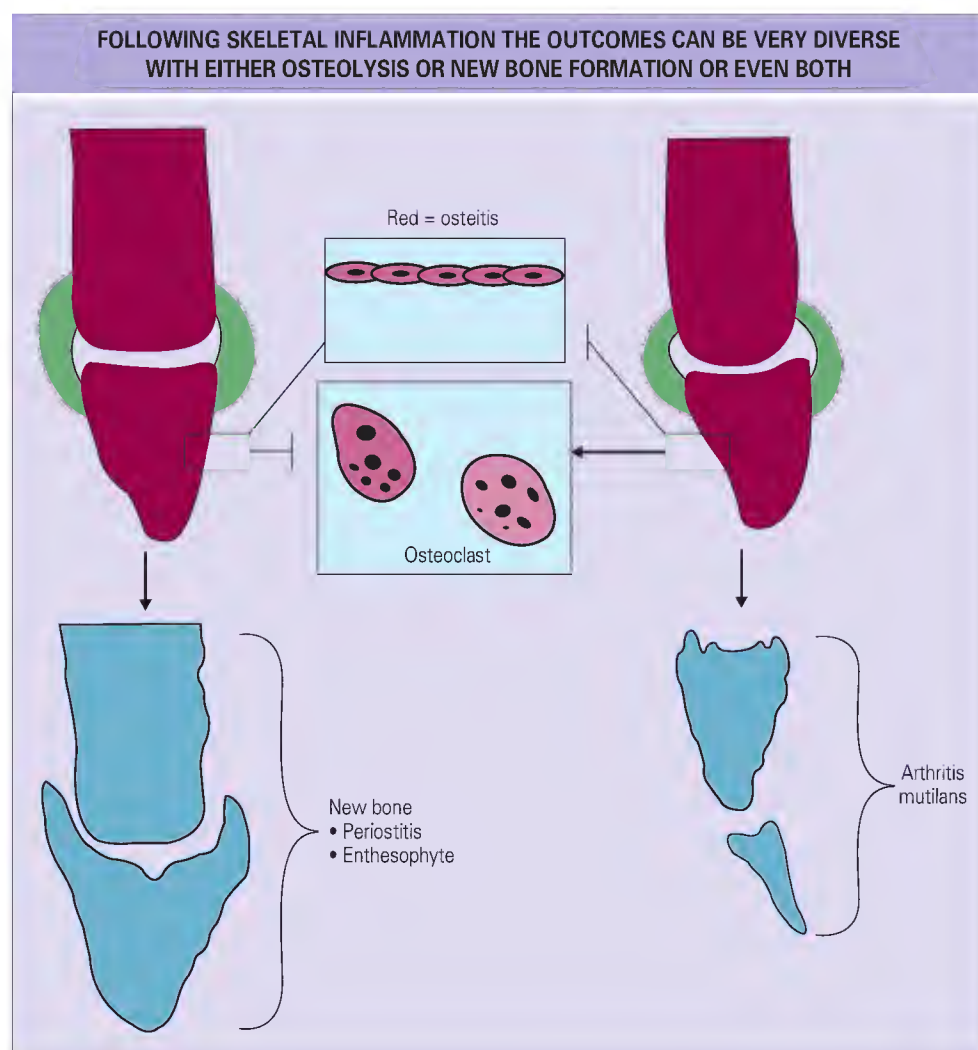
After diffuse digital osteitis (top left), tissue repair responses may dominate and lead to new bone formation at insertions and periostitis or even bony sclerosis (bottom left). This suggests a response that is ultimately dominated by osteoblastic and mesenchymal stem cell-mediated tissue repair responses. However, after diffuse osteitis the disease processes may be dominated by osteoclastic-mediated catabolic responses, with diffuse bone destruction leading to osteolysis and other characteristic radiographic changes, including bone whittling (bottom right). (Blue bone denotes bone after resolution of the active osteitis phase. Red bone denotes the active osteitis phase.)
